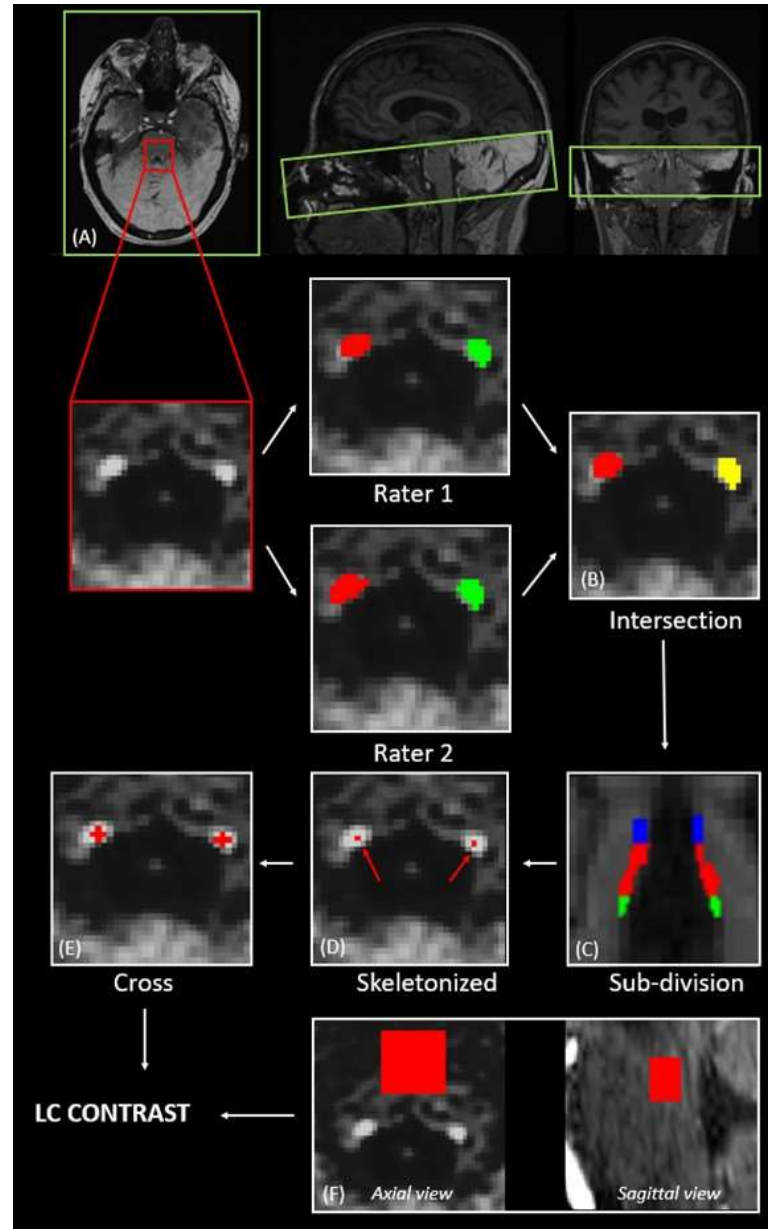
Extraction of the LC contrast. (A) Registration of the LC slab to the structural T1-weighted anatomical image (axial, sagittal and coronal views) ; (B) Computation of the intersection of the LC masks of two independent raters ; (C) Subdivision of the LC into rostral – 25 upper %
